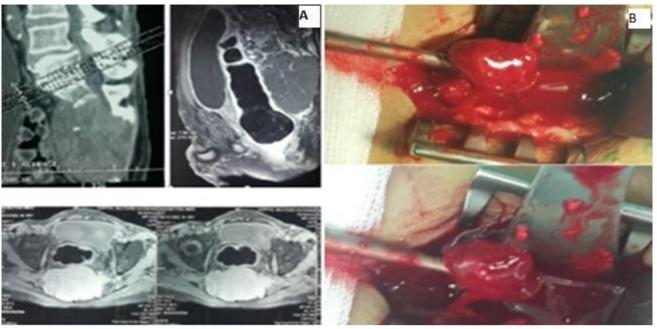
(A) a lumbar computed tomography (CT) scan and magnetic resonance imaging shows a heterogenous mass occupying The sacrum to the coccyx with 12-10-8 cm in size; (B) a needle biopsy revealed that this lesion was an infected metastatic carcinoid
